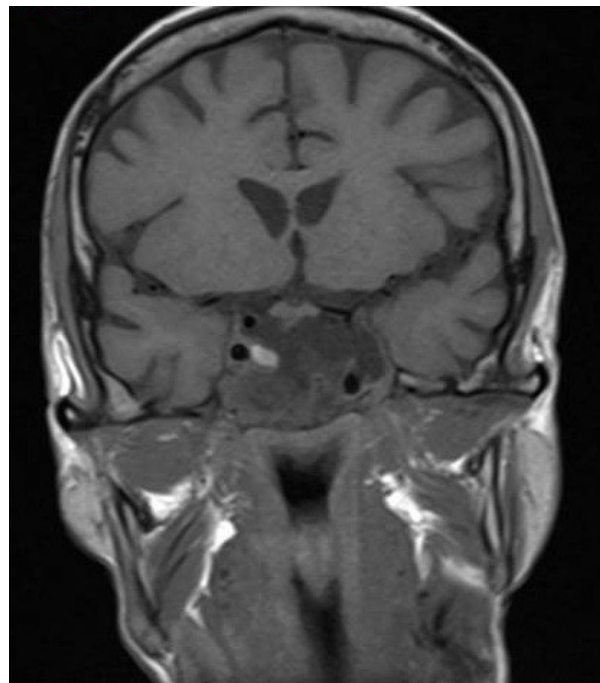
RM craneal 1.5 T. Coronal section MRI T1 sequence, showing bleeding within the macroadenoma, lateralized to the right.
